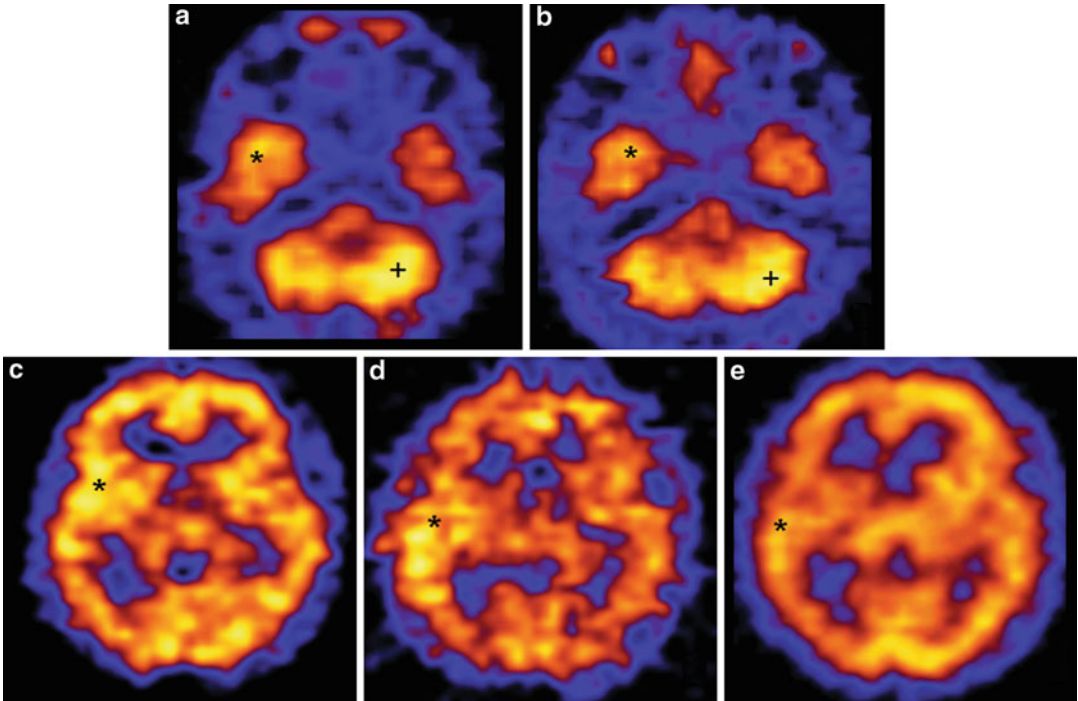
Hyperperfusion on interictal SPECT using ^{99m}Tc HMPAO and delayed postictal hyperperfusion after ictus. In a patient with surgically confirmed right temporal lobe epilepsy, on the fourth day after ictal study (a), axial images of the head taken on interictal SPECT (b) showed similar increased perfusion in the right temporal lobe (*)
